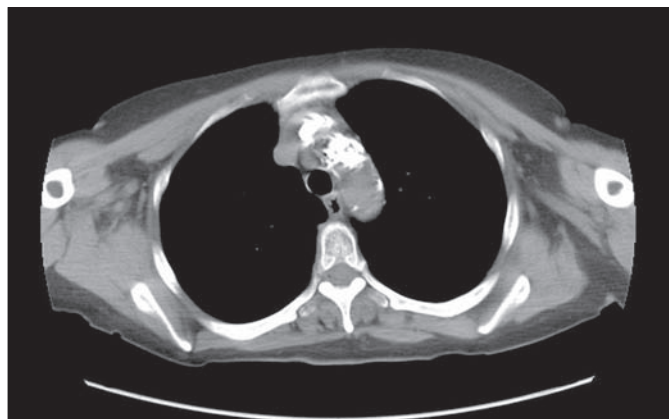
Axial computed tomographic frame showing heavy calcium deposits in the aortic arch.
